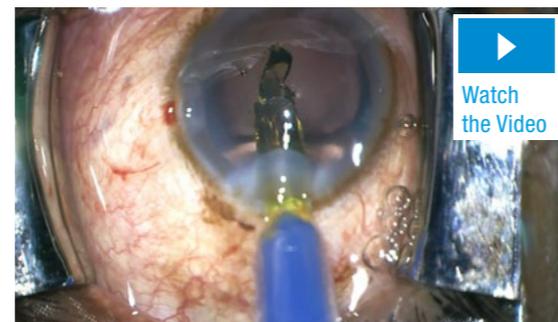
Implantation of the preloaded CT LUCIA 611P/PY
